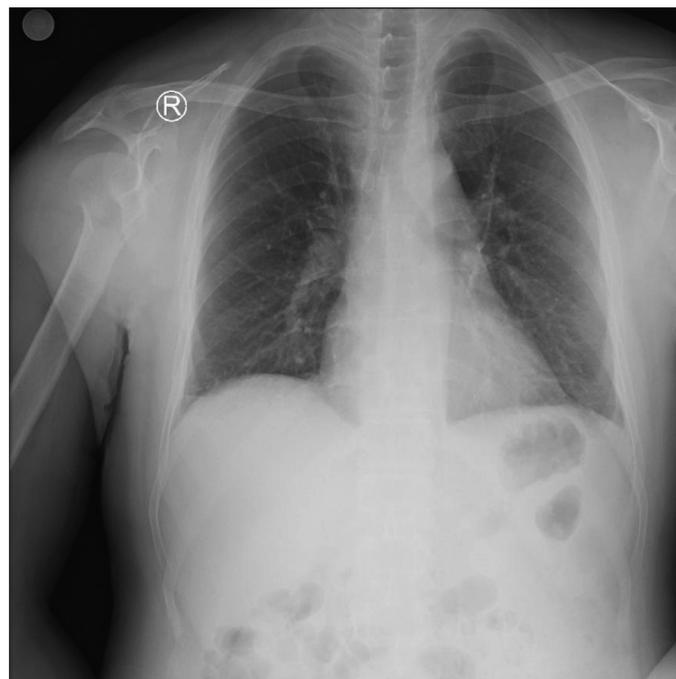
Chest X-ray was evaluated as normal
